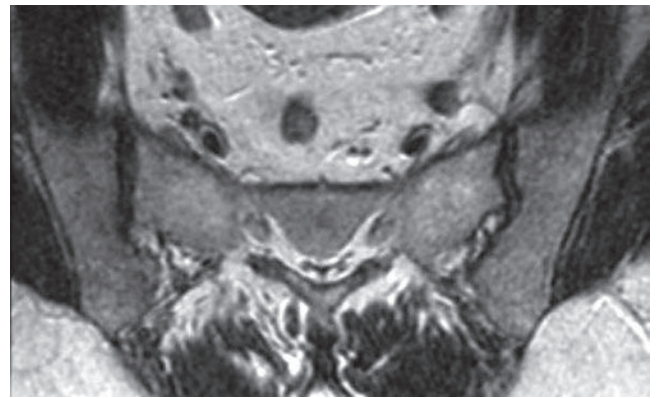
An axial T1-weighted image shows the normal appearance of the sacroiliac joints.
